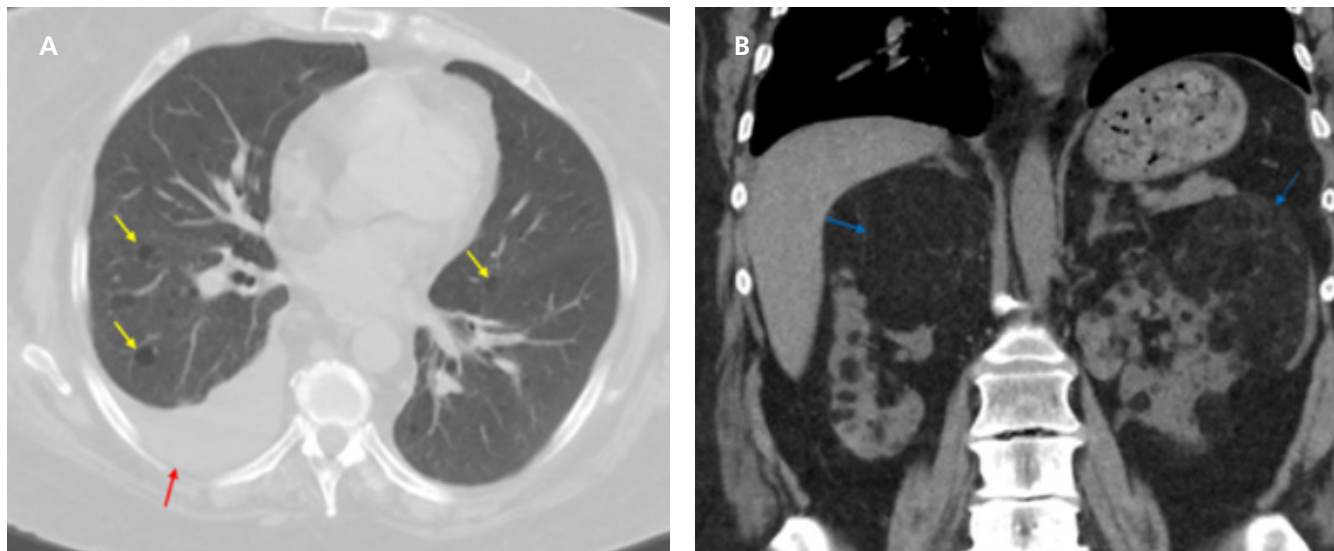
Lymphangiomyomatosis. (A) Axial unenhanced CT image in a patient with a history of tuberous sclerosis demonstrates multiple bilateral thin-walled pulmonary cysts (yellow arrows) and a right pleural effusion (red arrow). These patients can present with chyloous pleural effusions. Renal angiomyolipoma. (B) Coronal noncontrast CT image in the same patient demonstrating bilateral fat containing renal masses (blue arrows) compatible with angiomyolipomas.
